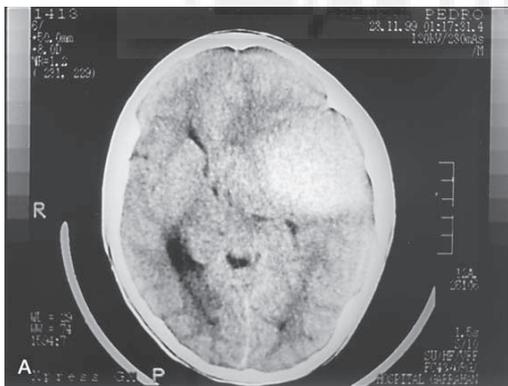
(A) Computed tomography scan, axial view, demonstrates gross temporal subdural hematoma in a 12-year-old male with headaches after mild head trauma. (B, C) Computerized tomography scan, axial view, performed 3 days after craniotomy and evacuation of the subdural hematoma, demonstrates an arachnoid cyst in the temporal fossa.
